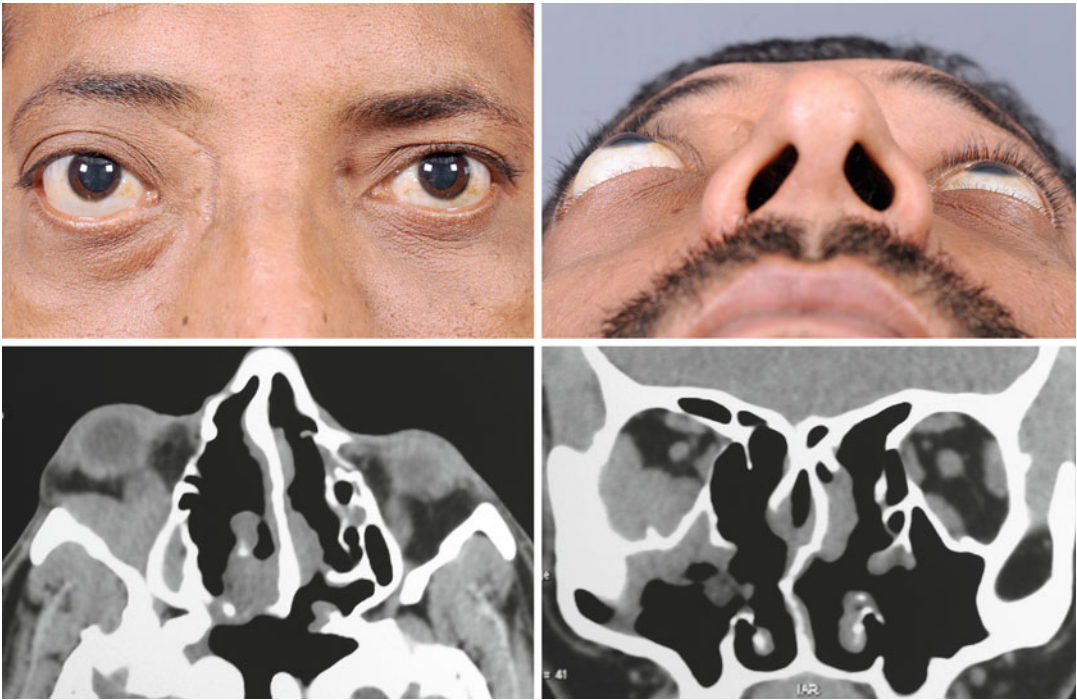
A 45-year-old immunocompetent nondiabetic male with a recurrent right proptosis. He had prior surgical removal of an ethmoid sinus mass through a medial orbitotomy. CT scan of the orbit showed an ill-defined
